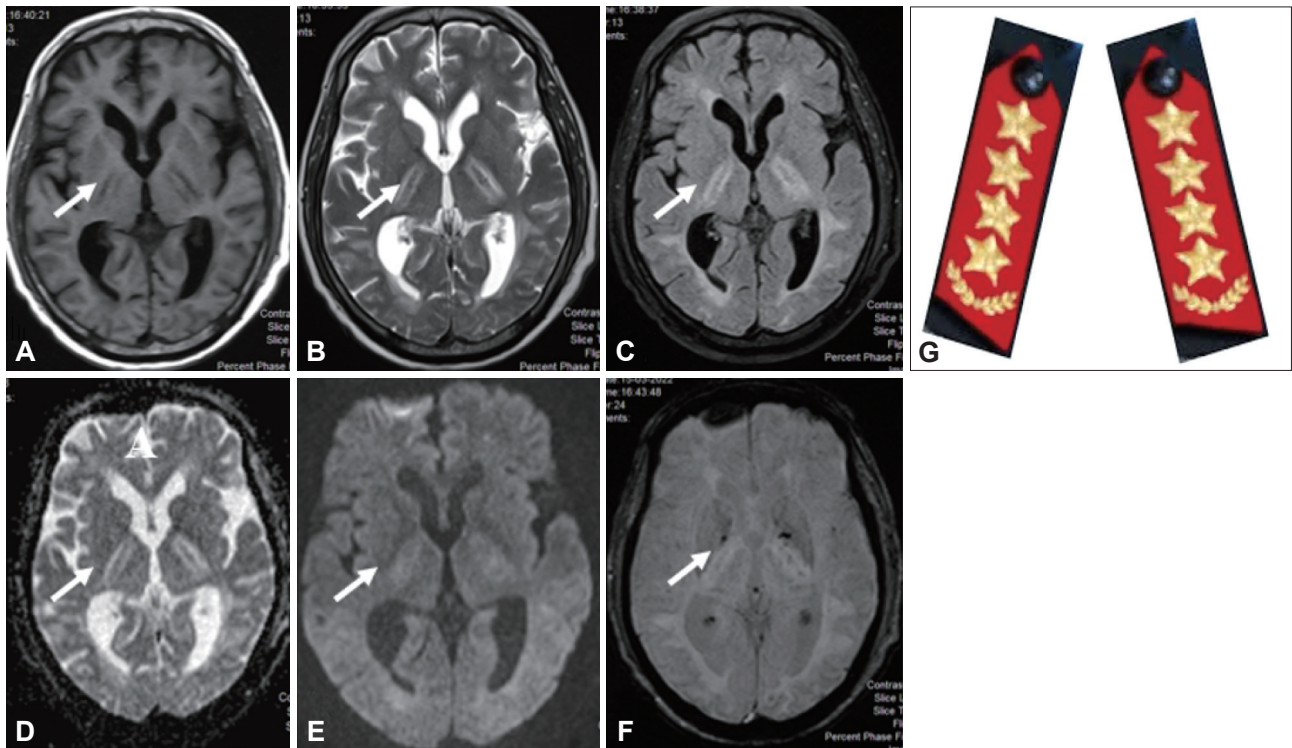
MRI images showing the “collar tab sign” (B,C), comprising T2-weighted/FLAIR HI that involve the bilateral internal capsules with corresponding hypointensities on a T1-weighted image (A), but not indicating diffusion restriction on diffusion-weighted images (D and E), with evidence of microbleeds in susceptibility-weighted imaging (arrows) (F). The HI have the appearance of the collar tabs worn on the collars of Indian army generals (G).
